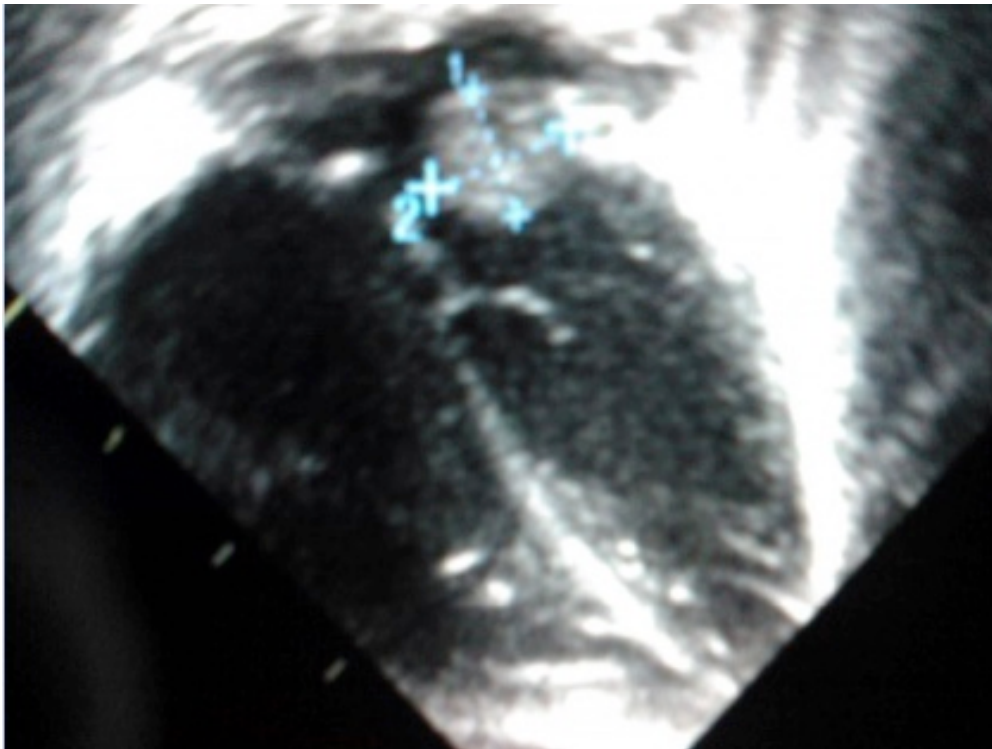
Apical 4-chamber view.
